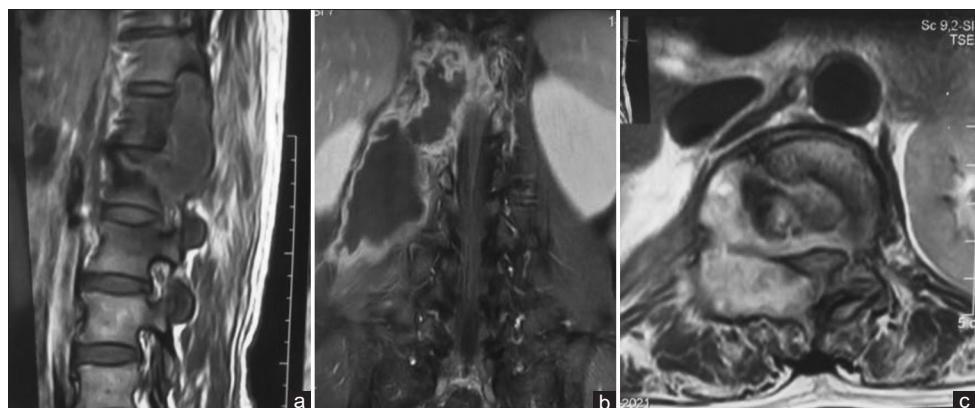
Sagittal (a), coronal (b), and axial (c) magnetic resonance imaging T2WI scans showing T11–T12 epidural abscess with concurrent discitis
